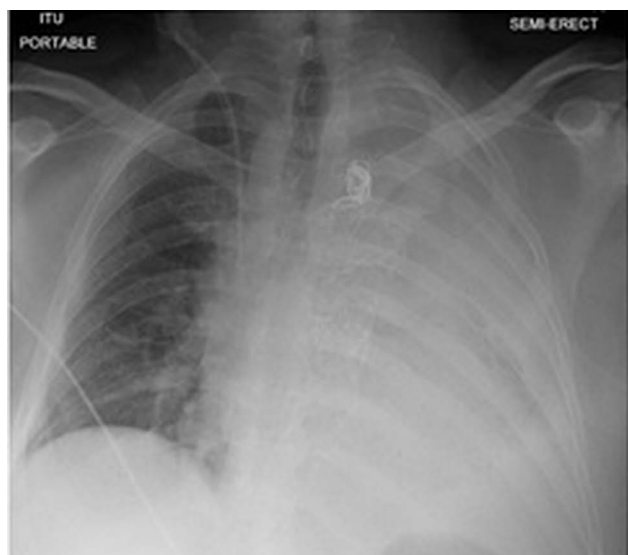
Chest radiograph done after the TEVAR depicts the stent and the coils in left subclavian artery in situ. The left opaque hemothorax is in keeping with left pleural effusion/hemothorax.
